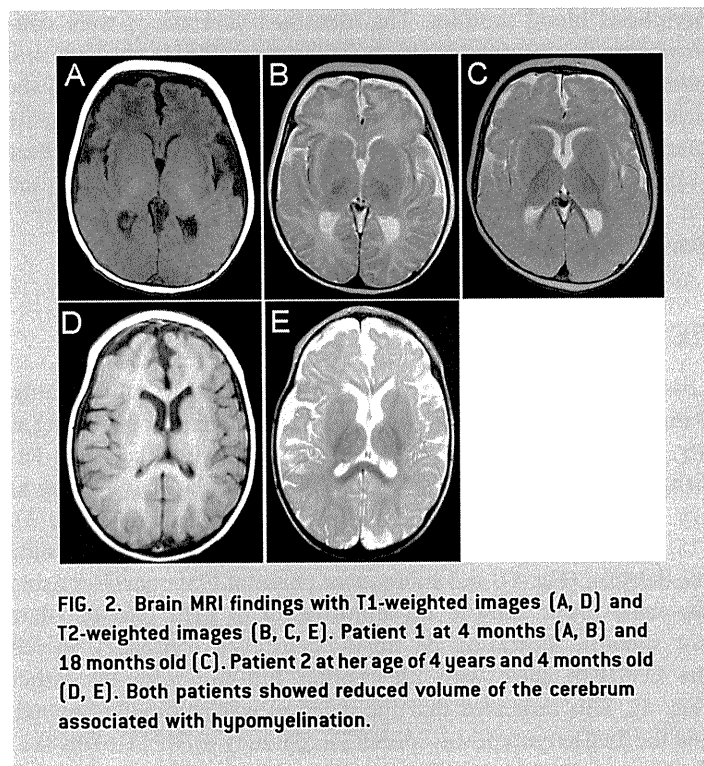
Brain MRI findings with T1-weighted images (A, D) and T2-weighted images (B, C, E). Patient 1 at 4 months (A, B) and 18 months old (C). Patient 2 at her age of 4 years and 4 months old (D, E). Both patients showed reduced volume of the cerebrum associated with hypomyelination.
